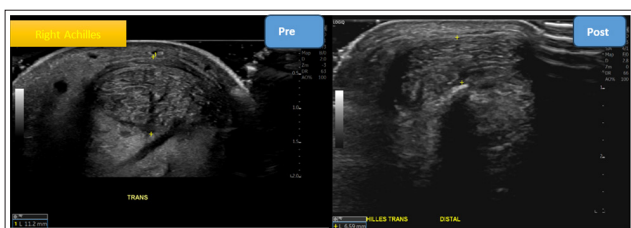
Pre- And Post-PRP Ultrasound Demonstrating a Reduction in Right Distal Achilles Tendon Thickness from 11.2 mm to 7.0 mm.
